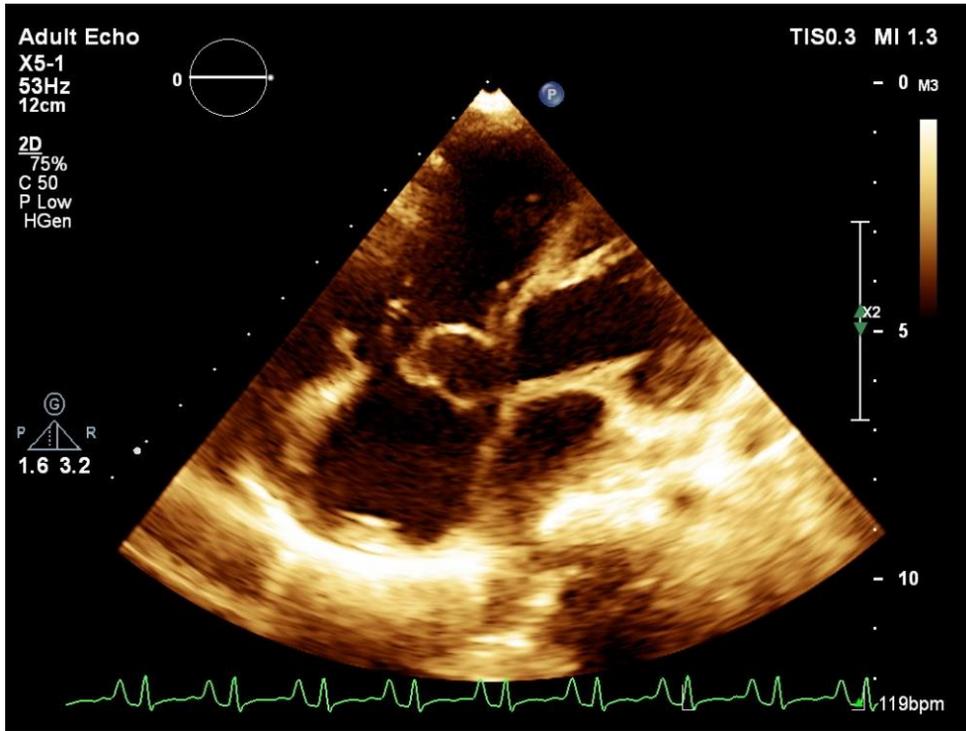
Two-dimensional echocardiography
